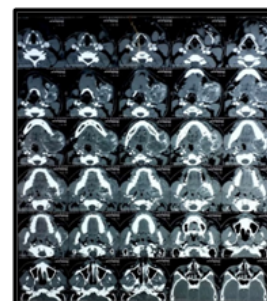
CT showing an expansile lytic lesion of left mandibular angle
